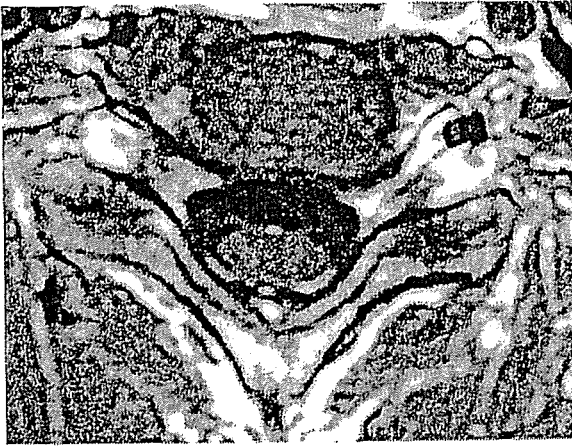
Gadolinium-diethylenetriaminepentaacetate (Gd-DTPA) enhanced T2-weighted magnetic resonance imaging at C6–7 levels. High intensity signals in C6 and C7 dorsal roots were observed on Gd-DTPA enhanced T2-weighted imaging (axial view), indicating on-going inflammation.
